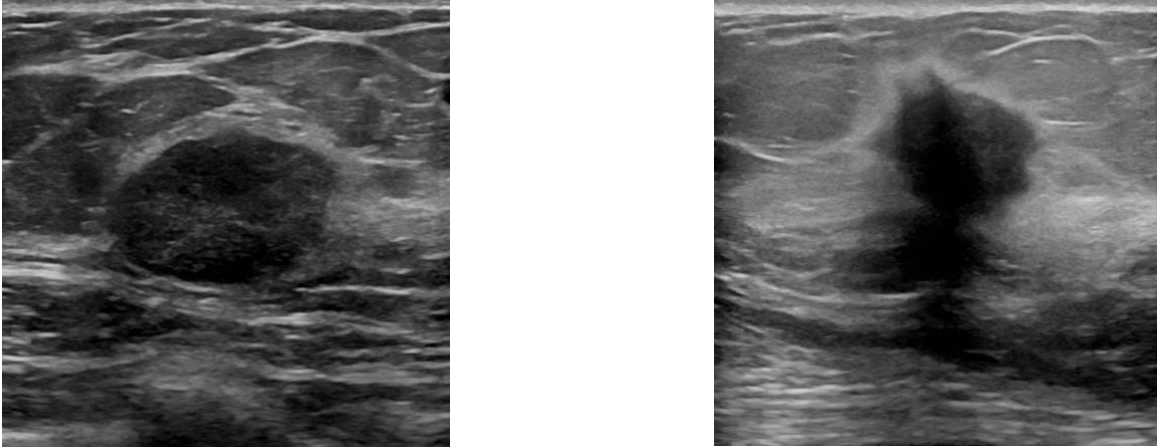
Sample ultrasound images from SCVMC dataset for each class, Benign (Left) and Malignant (Right)
